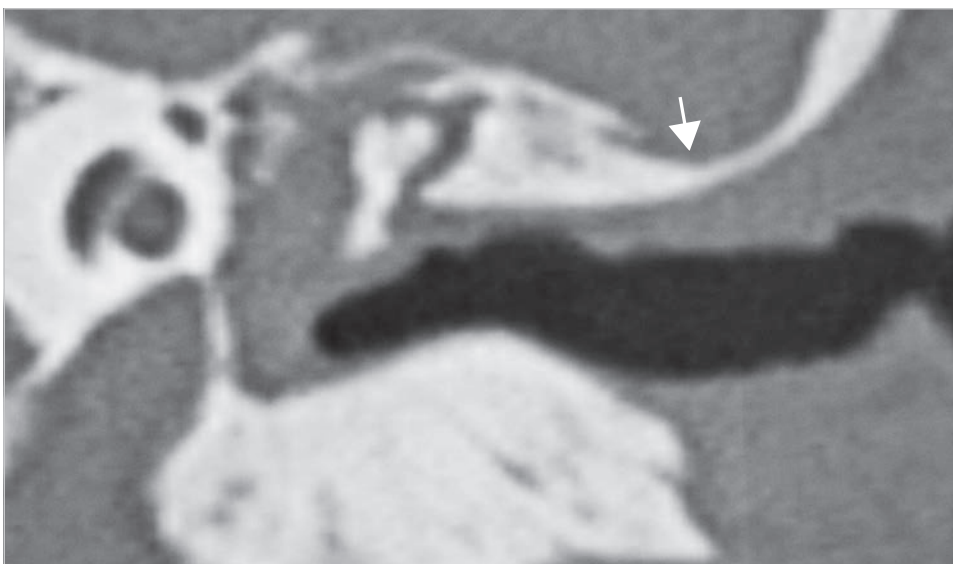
The coronal CT shows very low middle fossa dura (arrow) limiting access to the attic.
